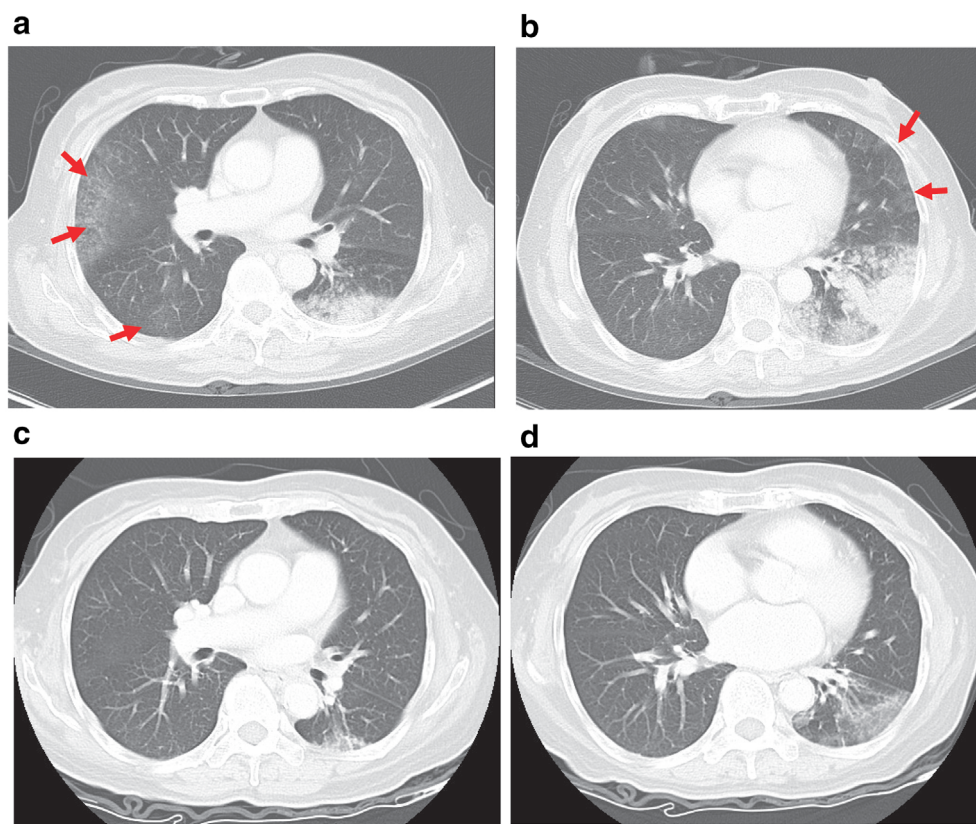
A 73-year-old female patient who had *EGFR*-mutant lung cancer (exon 19 deletion T4N3M1a stage IVA) and underwent targeted therapy with afatinib. (a, b) CT scans: Left lower lobe lobar invasion with multiple lung metastasis (red arrows); (c, d) CT scans: Shrinkage of main tumor and complete disappearance of lung metastasis. The patient remains under *EGFR*-TKI treatment and is free of recurrence 4.5 months after undergoing a left lower lobectomy.
